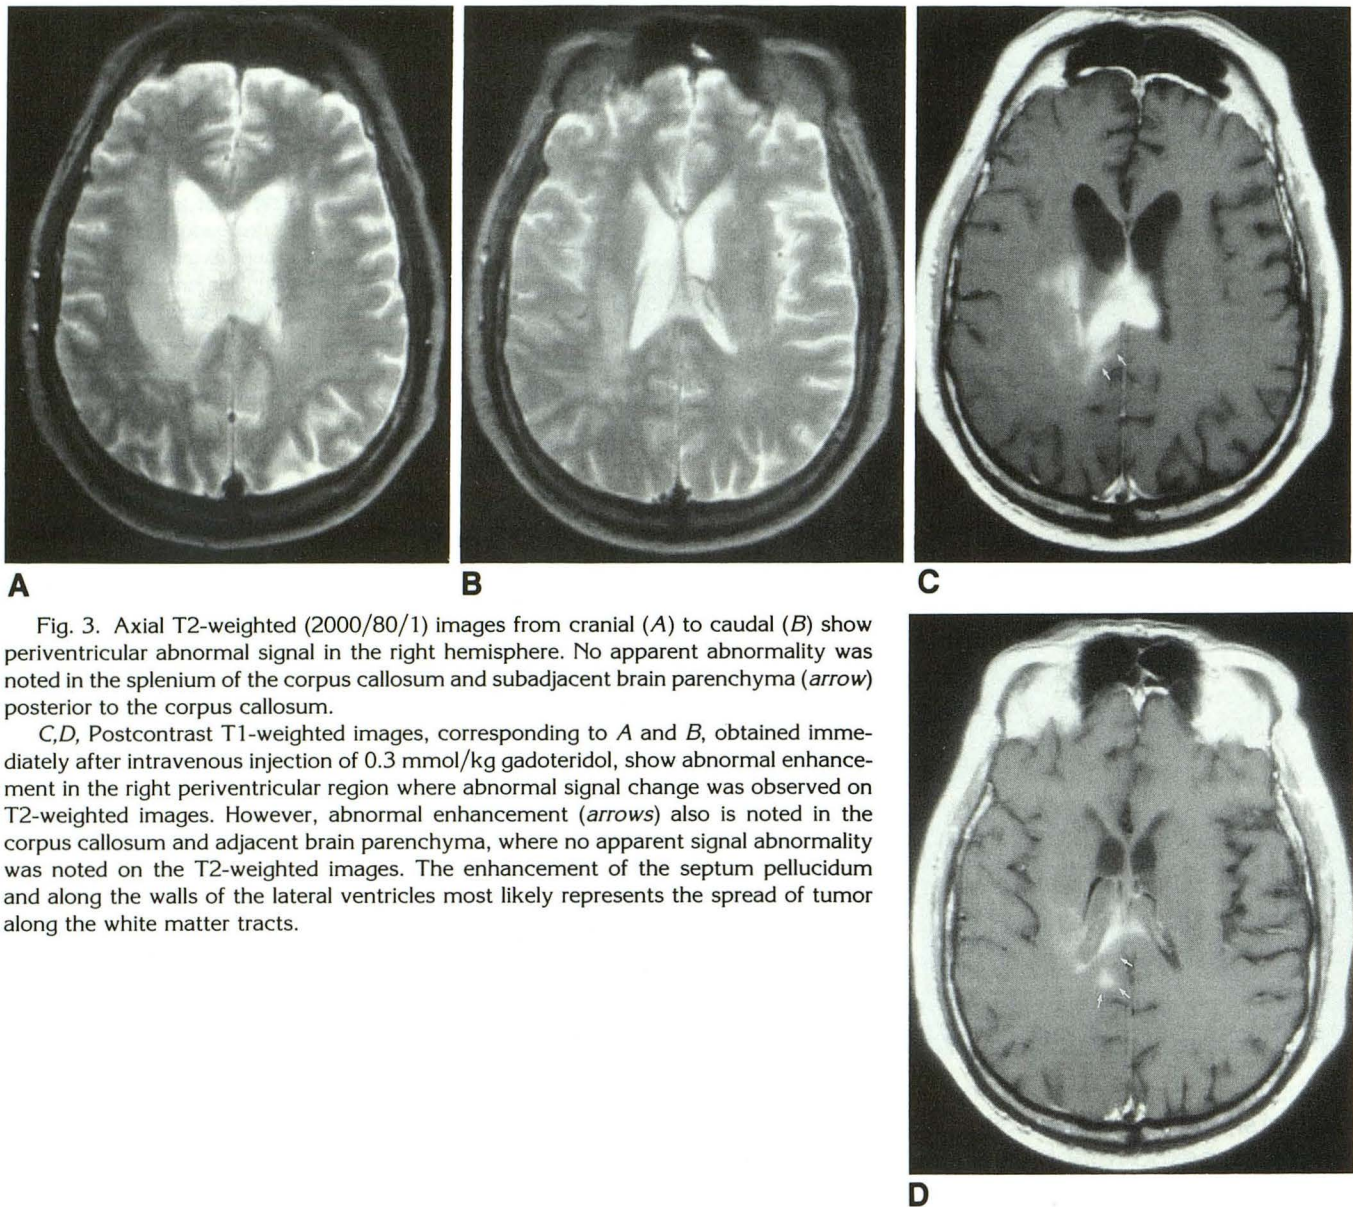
Axial T2-weighted (2000/80/1) images from cranial (A) to caudal (B) show periventricular abnormal signal in the right hemisphere. No apparent abnormality was noted in the splenium of the corpus callosum and subadjacent brain parenchyma (arrow) posterior to the corpus callosum.
